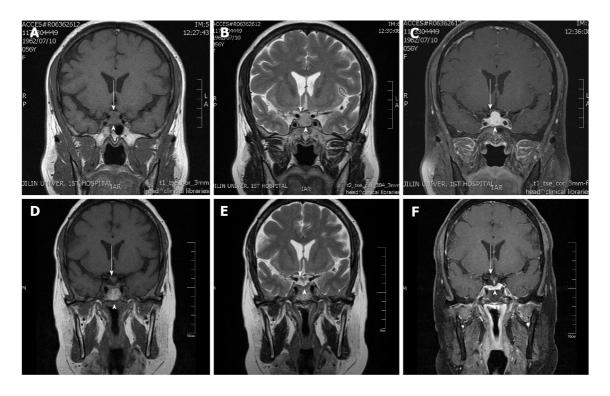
Pretreatment coronal magnetic resonance imaging showing pituitary enlargement (arrowhead) and optic chiasm elevation (arrow). A: In the T1 sequence; B: In the T2 sequence; C: Postgadolinium-enhanced coronal magnetic resonance imaging showing an enlarged pituitary gland with significant homogeneous enhancement (arrowhead) and an elevation of the optic chiasm (arrow); D: Posttreatment coronal magnetic resonance imaging showing an almost normal pituitary gland in the T1 sequence; E: Posttreatment coronal magnetic resonance imaging showing an almost normal pituitary gland in the T2 sequence; F: With gadolinium enhancement in the coronal position.
